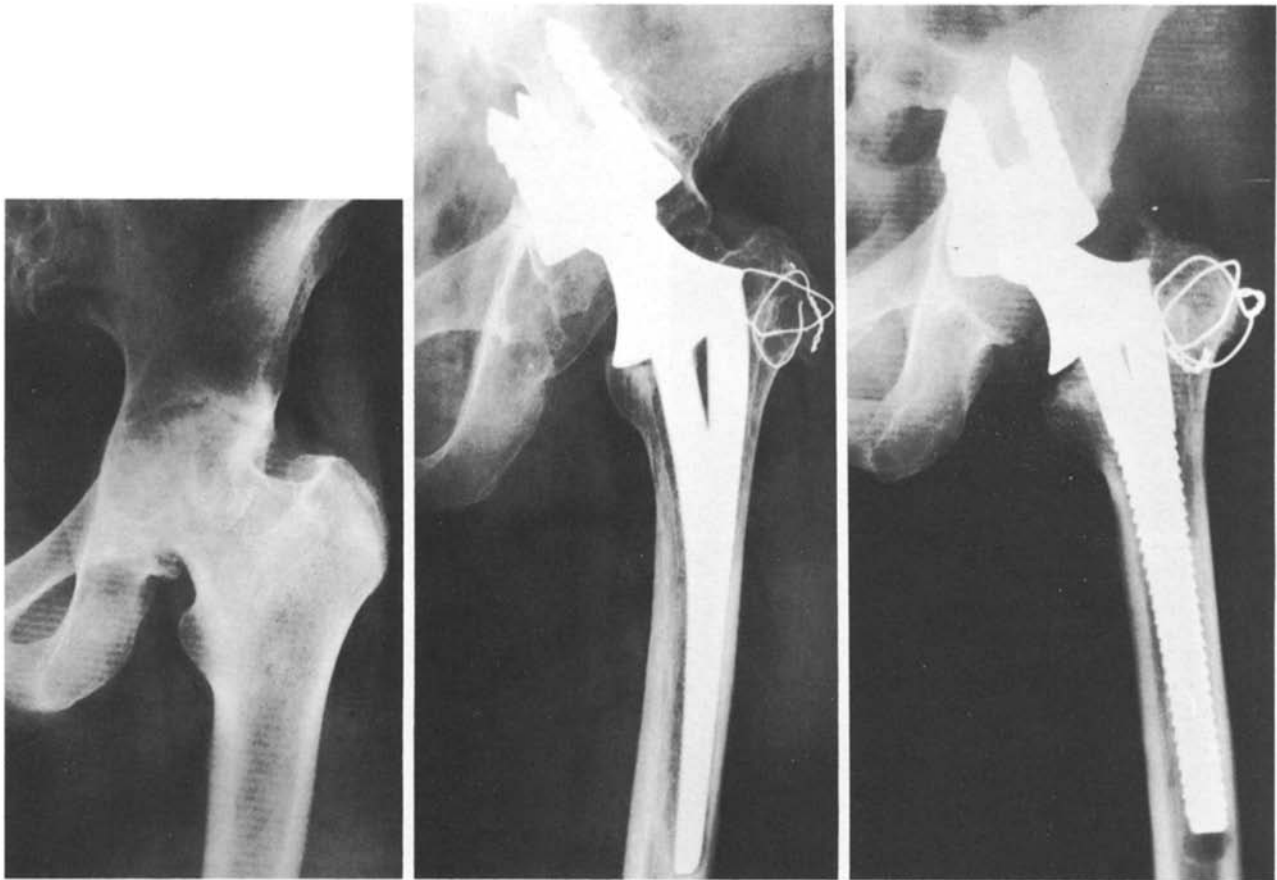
Loosening was suspected in this case. Female, 42 years old, rheumatoid arthritis. She has moderate pain when walking, and X-ray picture shows radiolucency around the femoral component. Left: before surgery. Middle: 3 years after surgery: our old total hip prosthesis was used. Right: 1 year after second surgery: our new total hip prosthesis was used
